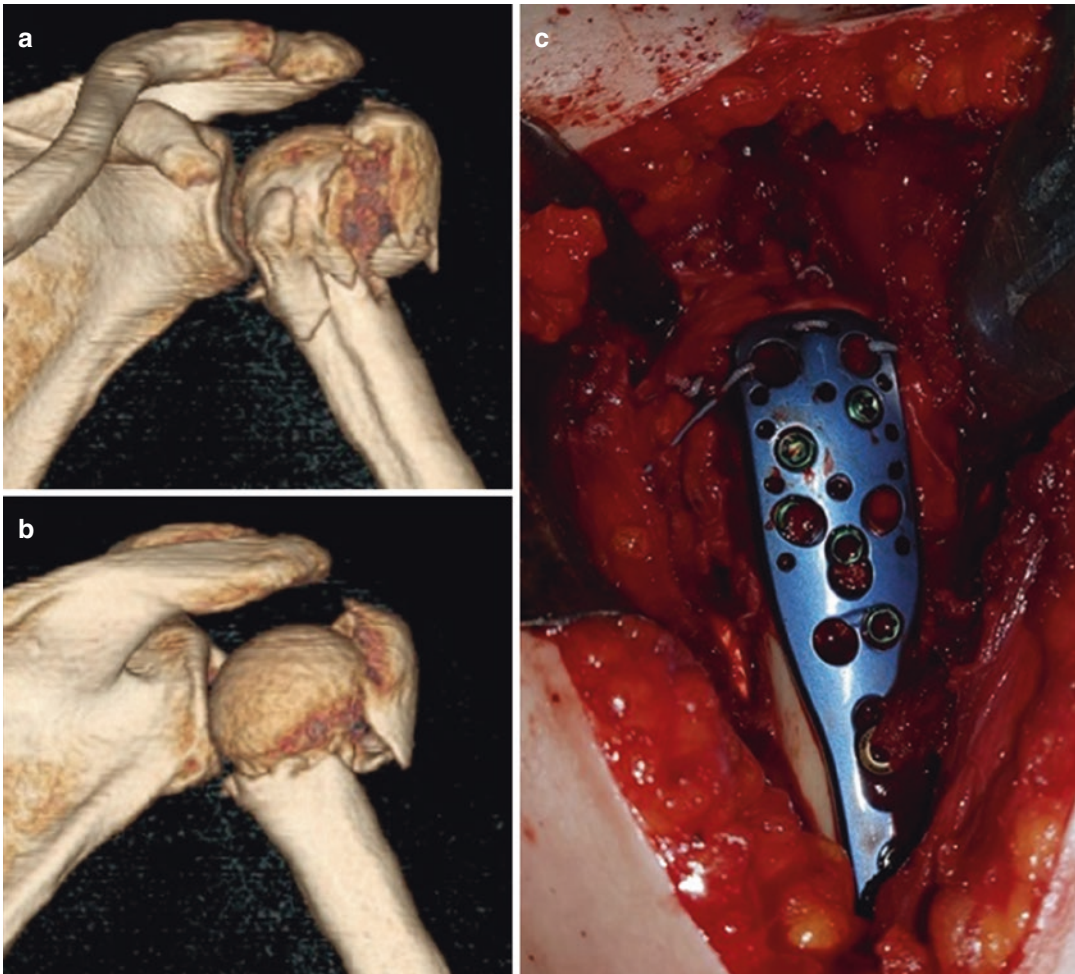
A 67-year-old woman's four-part proximal humerus fracture. Preoperative, anterior (a) and posterior view (b) of the fracture site. 3D CT scan (c). Anterior radiogram after plate fixation (d). Lateral radiogram after plate fixation (e)
